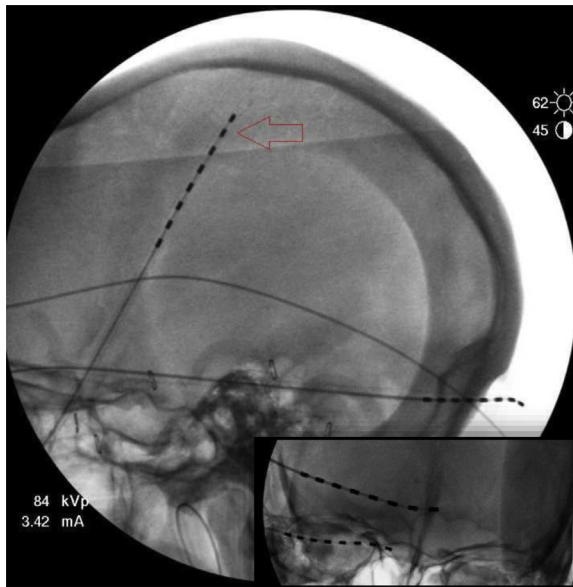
Lateral X-ray showing location of stimulator array, which was placed percutaneously underneath the patient's scalp based on pre-operative mapping of trigger points. AP insert showing occipital and supraorbital nerve leads.
